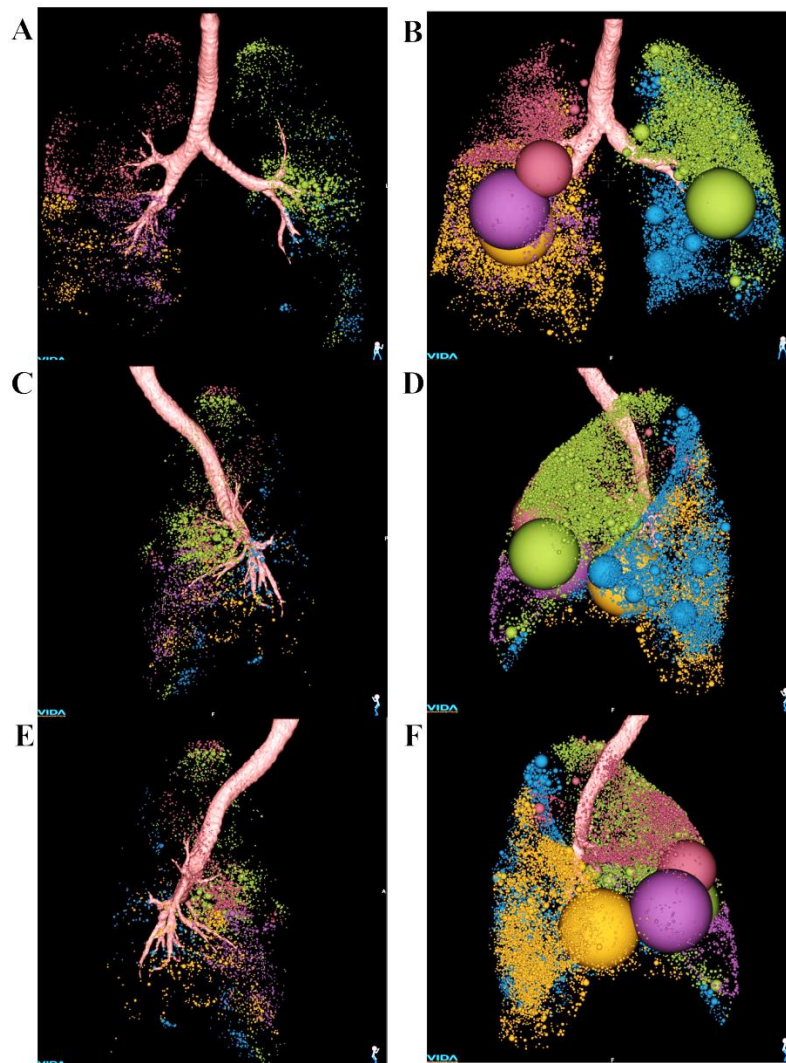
Frontal views (A, B), Left lateral views (C, D) and right lateral views (E, F) of air-trapped regions captured by CT intensity at FRC image  $< -856$  HU, from Apollo (Vida Diagnostics). A, C and E: *AirT%* of a normal subject: total, 0.5 %; LUL, 0.9 %; LLL, 0.2 %; RUL, 0.6 %; RML, 1.3 %; RLL, 0.3 % (*AirT\: LUL, 37.6 %; LLL, 7.8 %; RUL, 20.7 %; RML, 17.0 %; RLL, 16.9 %) and B, D and F: *AirT%* of a severe asthmatic subject: total, 14 %; LUL, 14.4 %; LLL, 5.0 %; RUL, 9.3 %; RML, 39.9 %; RLL, 14.9 % (*AirT\: LUL, 24.1 %; LLL, 7.8 %; RUL, 11.6 %; RML, 27.5 %; RLL, 29.0 %). Lobes are color-coded: LUL (green), LLL (blue), RUL (red), RML (purple) and RLL (orange).
